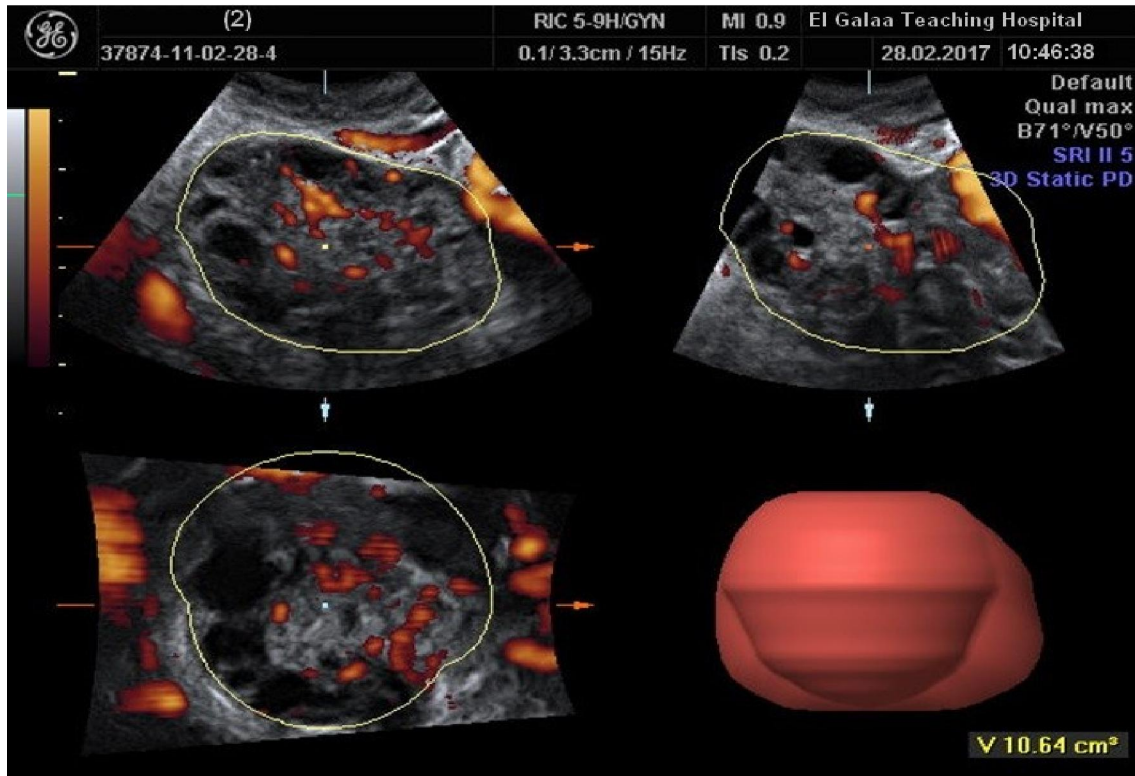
Volume measurement by 3D ultrasound
